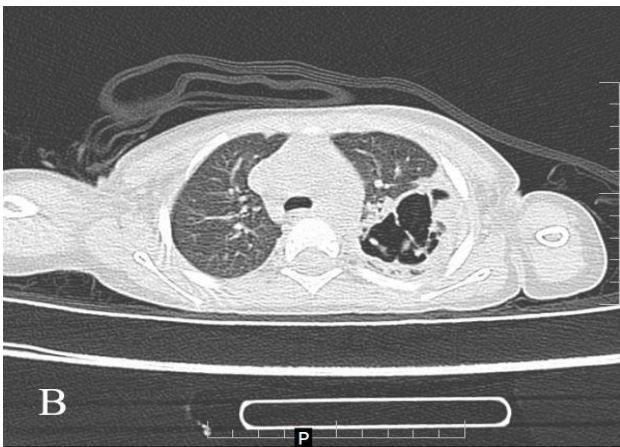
CT thorax showing consolidation with a large cavity in posterior segment of left upper lobe with multiple septations.
